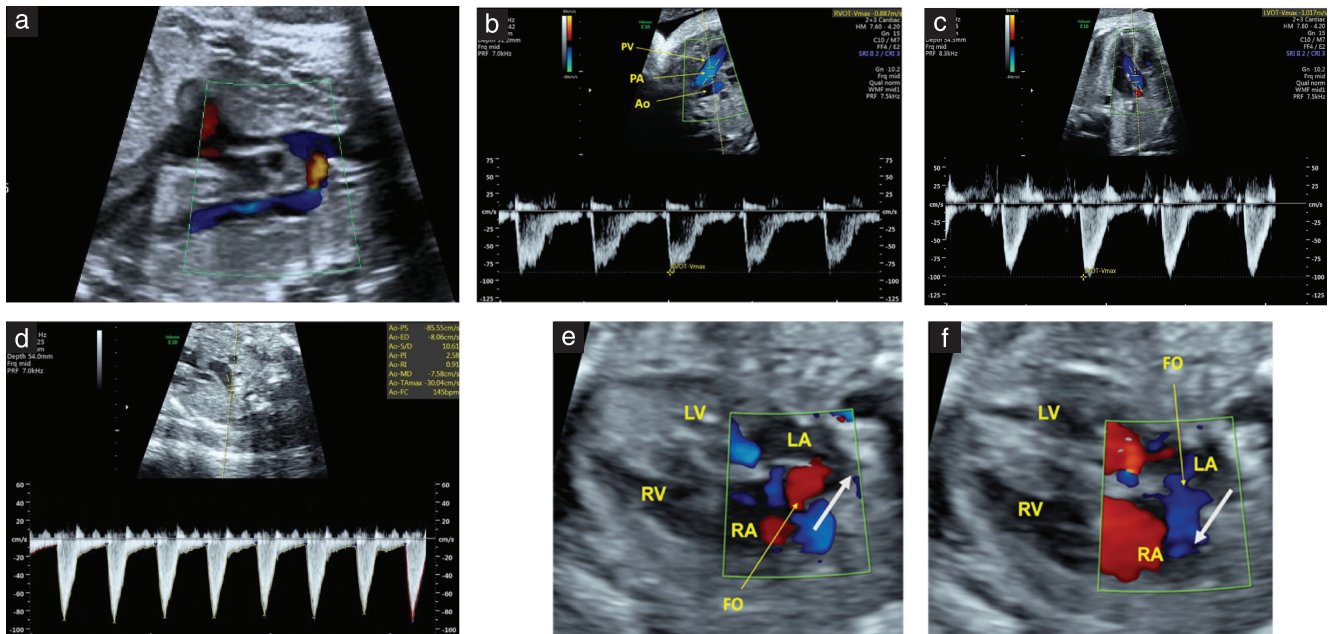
Color (a,e,f) and pulsed (b–d) Doppler parameters that were evaluated as predictors of coarctation of aorta, including: (a) bidirectional flow at aortic arch; (b) main pulmonary artery (PA) peak velocity; (c) ascending aorta peak velocity; (d) laminar flow in aorta; and (e,f) bidirectional flow at foramen ovale (FO) (arrows indicate flow direction). Ao, aorta; LA, left atrium; LV, left ventricle; PV, pulmonary valve; RA, right atrium; RV, right ventricle.
